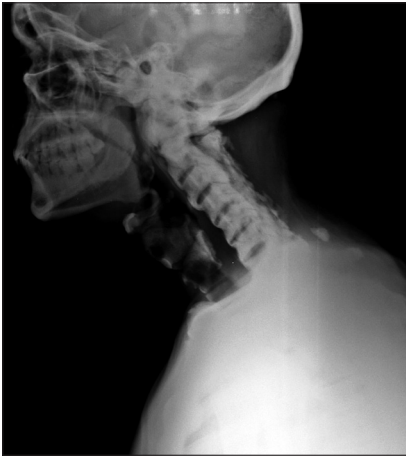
X-ray Cervical spine lateral view reveals- osteosclerosis with post op defect of laminectomy with ossification of interspinous ligament, anterior longitudinal ligament.
